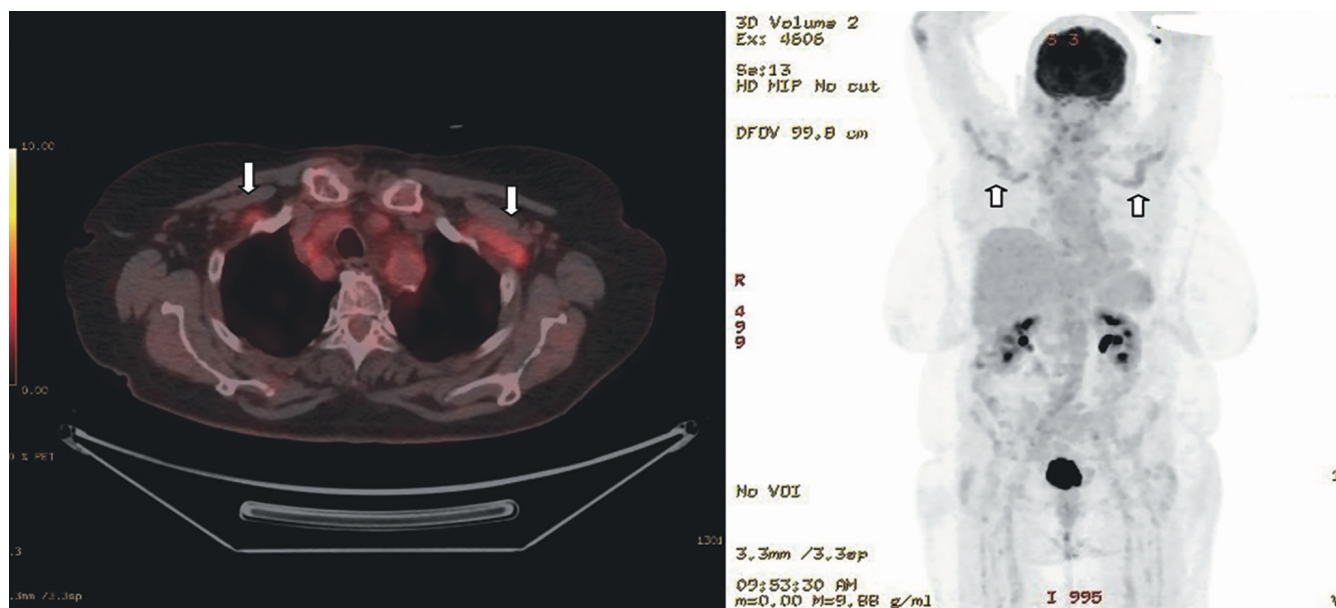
FDG-PET scan depicting an increased uptake of the FDG radionuclide in the subclavian arteries (arrows).
